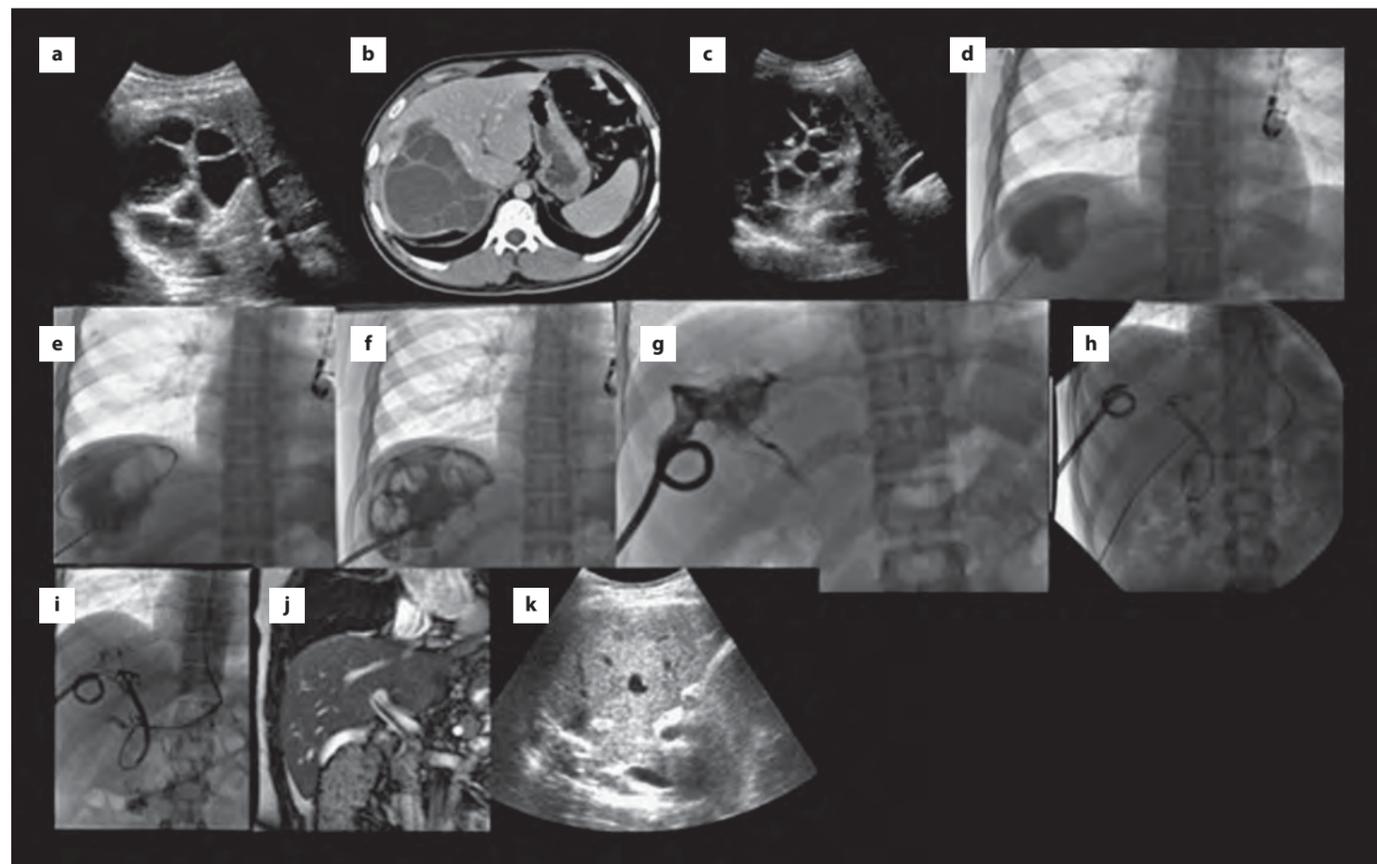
CE2 cyst was detected on abdominal US (a) and CT (b) examination of the 30-year-old male patient. Percutaneous treatment was performed by MoCaT technique. Puncture was performed with an 18-G Seldinger needle under US guidance (c). Contrast media was then injected into the cavity (d). A 0.035-inch Amplatz guide-wire was advanced under the fluoroscopy guidance (e). After tract dilatation, a 14 Fr pigtail catheter was advanced over the guide wire and placed within the cavity (f). "Effective and aggressive irrigation of the cavity", was performed for evacuation of the content. Cysto-biliary fistula was detected 3 days after the procedure (g). The patient was referred to the gastroenterology and endoscopic papillotomy and naso-biliary catheter placement were performed to reduce biliary pressure (h). Cysto-biliary fistula was healed and the cavity totally collapsed 14 days after the endoscopic procedure (i). Amount of daily drainage dropped below 10 mL and the catheter was withdrawn. Complete resolution of the cyst was seen on follow-up (36 months after percutaneous treatment) MR (j) and US (k).
